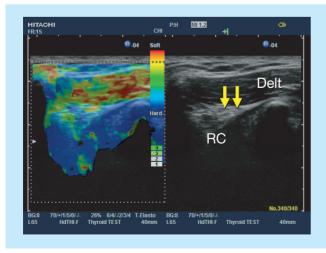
Short-axis ultrasound Elastography shows different tissue elasticity among deltoid muscle (Delt), coracoacromial ligament (arrows), and rotator cuff tendon (RC).
